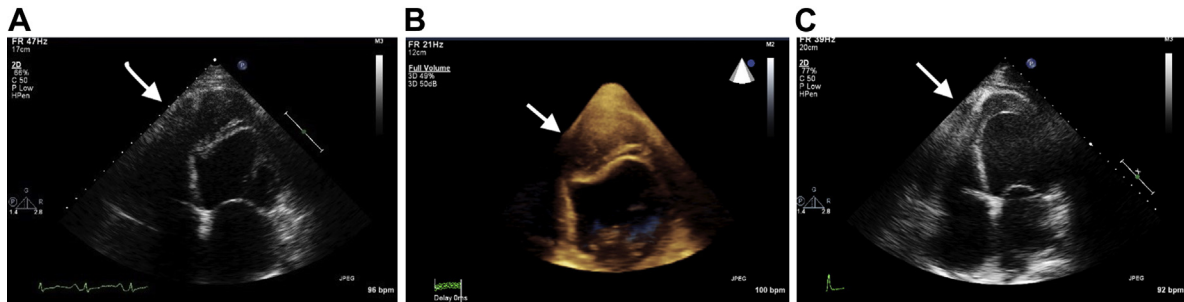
(A) Transthoracic two-dimensional echocardiographic views of intramyocardial dissection (*arrow*). (B) Transthoracic three-dimensional echocardiography showing a mobile endocardial flap with intramyocardial dissection cavity with spontaneous echocardiographic contrast (*arrow*). (C) Increased echogenicity over the apex (*arrow*), consistent with thrombus formation at 3-month follow-up.
